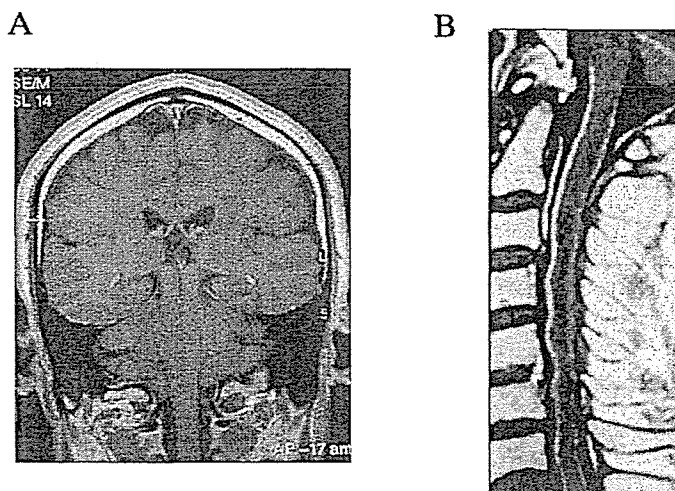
Changes in the leptomeninges as evidenced by magnetic resonance imaging (MRI) before and after liver transplantation. Gadolinium enhanced MRI ( $T_1$ ) before (A) and 1.5 years after liver transplantation (B) in a 50-year-old female FAP patient (no. 17).
